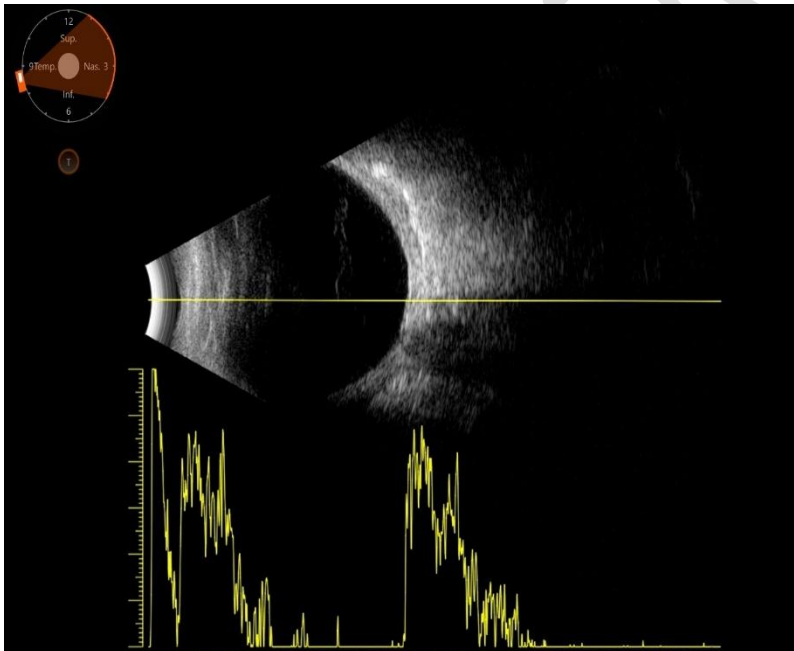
B mode ultrasound showing resolving suprachoroidal hemorrhage at postoperative 40th day
